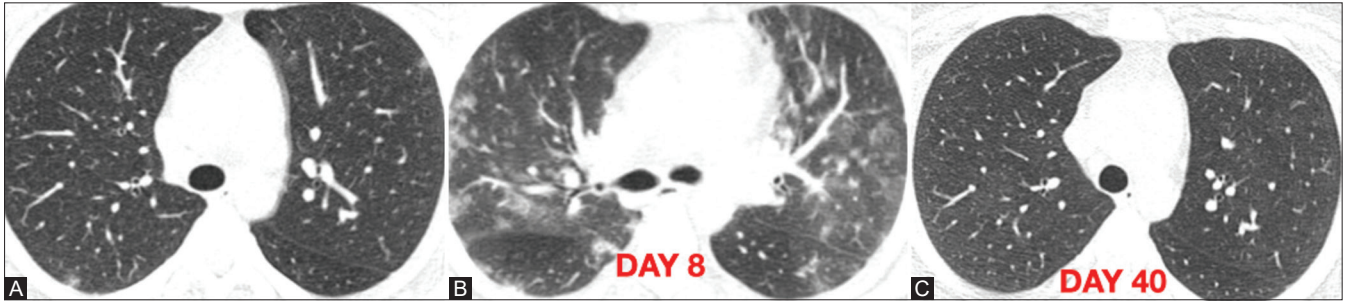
(A-C): HRCT (A) demonstrates subtle ground-glass densities in right posterior subpleural region of lower lobe. HRCT (B) 8 days later, COVID-19 pneumonia evolves with subpleural and peribronchovascular ground-glass densities and consolidations. HRCT (C) 40 days after first scan reveals total resolution of abnormalities
